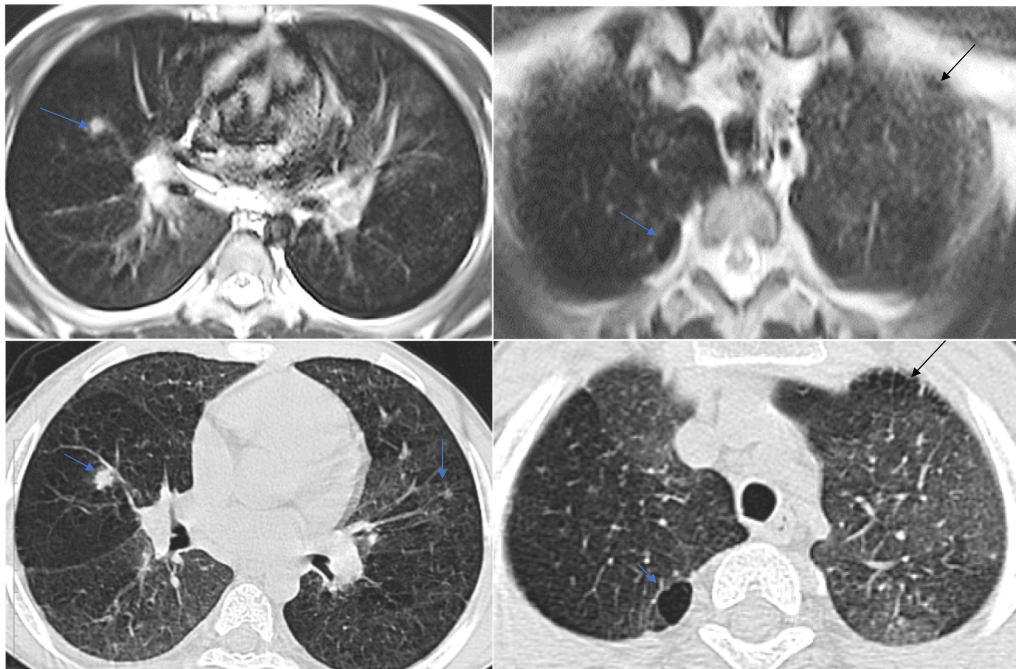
A 11-year-old male with chronic airway disease secondary to autoimmune disease, T2 HASTE, and comparable HRCT cut; both show the middle lobe air trapping, bilateral nodules better delineated by CT (blue arrows), and bilateral apical subpleural blebs (black arrows). CT score 12, MRI score 9
